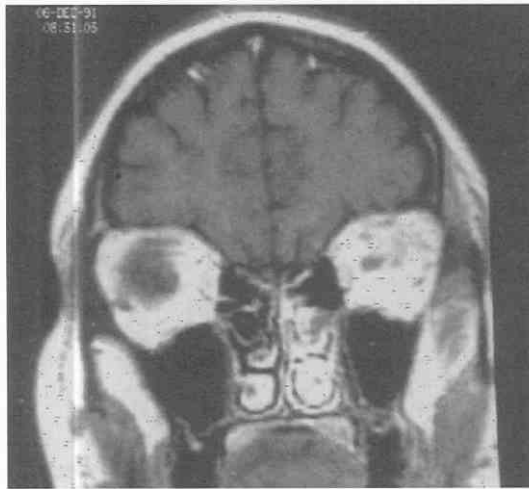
Normal MRI study. This T1-weighted image (TR500, TE32) was obtained in the coronal plane following contrast injection. The vascular nature of the turbinates is manifested as intense enhancement following contrast injection. The turbinates and nasal mucosa alternately engorge with blood and then shrink. This patient may be in the left-sided engorgement phase of the nasal cycle. Note the enlarged turbinates and thickened nasal mucosa.
